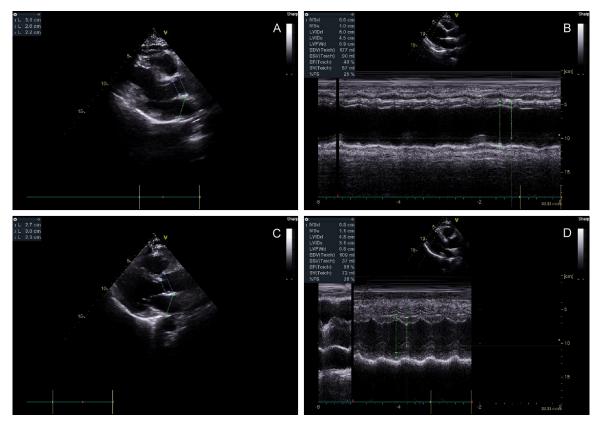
Echocardiographic changes before and after treatment in a patient with heart failure following PCI. A, B: Pre-treatment echocardiography (Dec 2019); C, D: Post-treatment echocardiography following 3-month combined dapagliflozin and sacubitril/valsartan therapy. PCI, Percutaneous Coronary Intervention.
